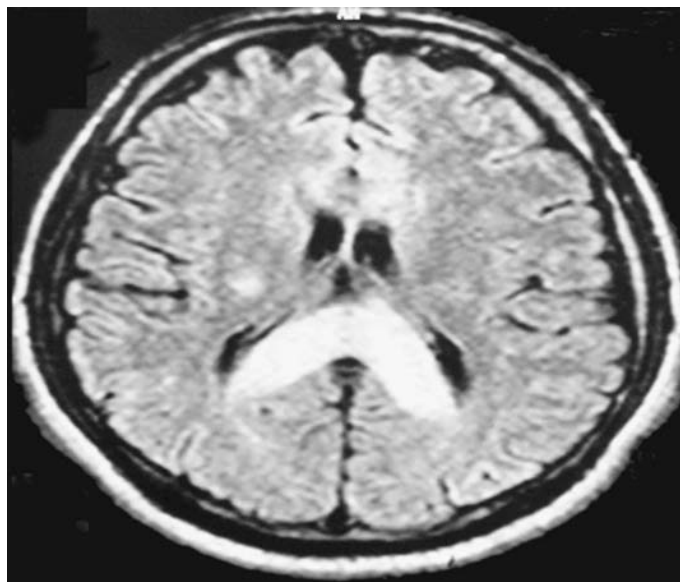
T2 magnetic resonance image of the brain of a patient with high-altitude cerebral edema (HACE) shows marked swelling and a hyperintense posterior body and splenium of the corpus callosum (area with dense opacity). The patient, a climber, went on to climb Mount Everest about 9 months after this episode of HACE. (Source: FJ Trayers 3rd: *Wilderness preventive medicine*. *Wilderness Environ Med* 15:53, 2004.)
